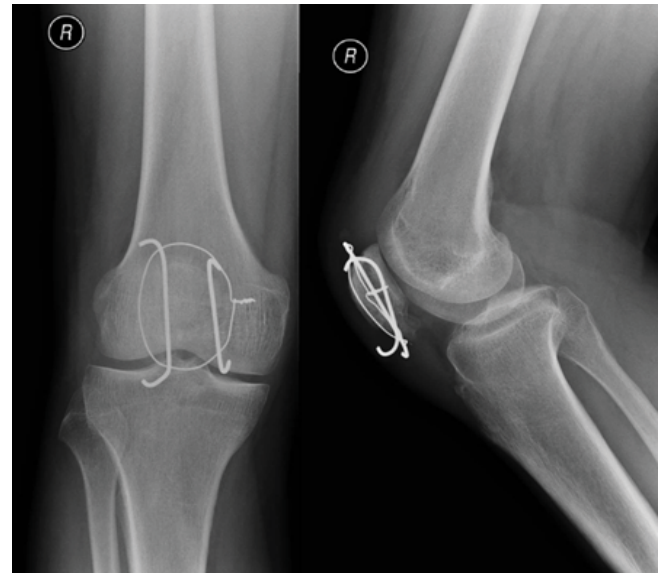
Anteroposterior and lateral plain film radiographs of a TBW fixation.
